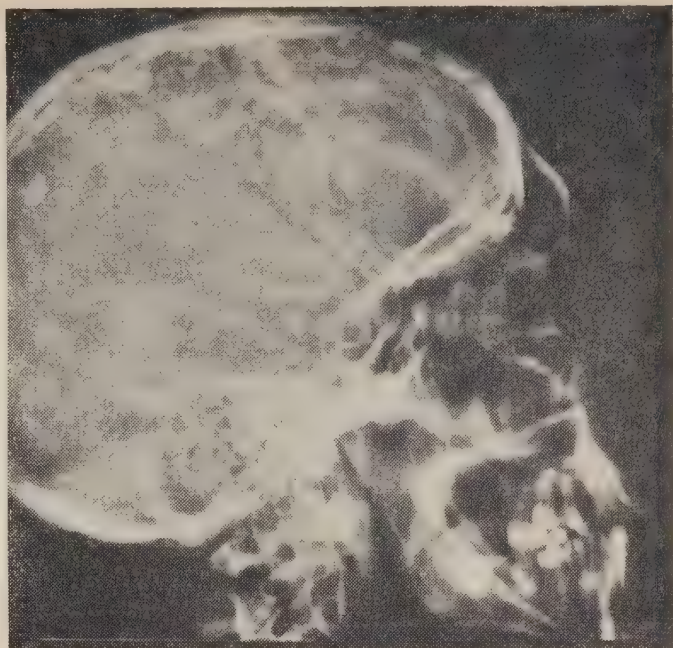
Lateral skull radiograph showing generalized dural calcifications.
